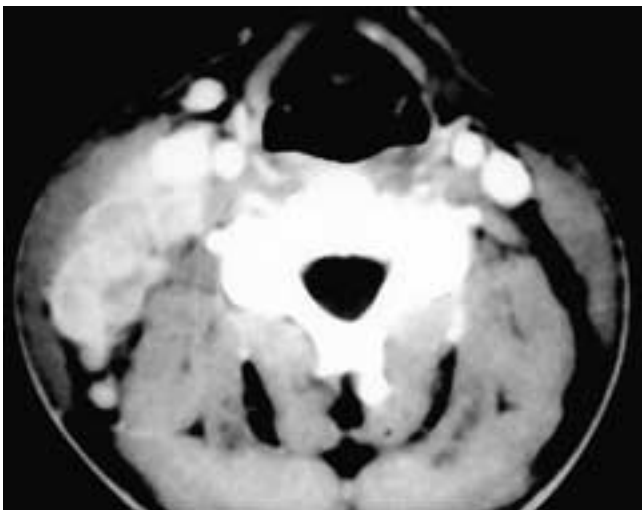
Axial contrast-enhanced CT scan shows multiple nonhomogeneously enlarged right level II nodes. Anteriorly, there is some involvement of the adjacent fat planes. The enhancing nodal capsules give an appearance suggesting numerous "rings" within the nodal mass, a sign highly suggestive of nodal disease. This patient had Hodgkin's disease.
